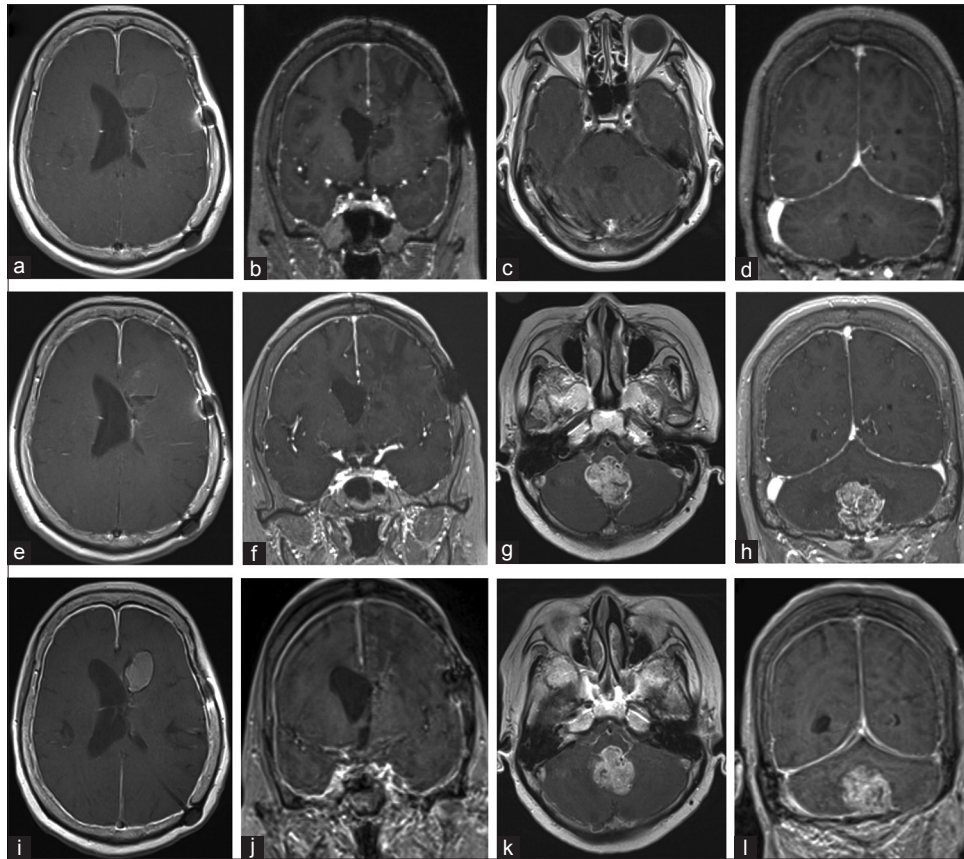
MRI of the brain from 5 years and 8 months to 6 years and 8 months after diagnosis. Gadolinium-enhanced T1-weighted MRI. (a-d) Five years and 8 months after diagnosis ([a and c] axial section, [b and d] coronal section). (e-h) Six years and 4 months after diagnosis ([e and g] axial section, [f and h] coronal section). (i-l) Six years and 8 months after diagnosis ([i and k] axial section, [j and l] coronal section). MRI – Magnetic resonance imaging
